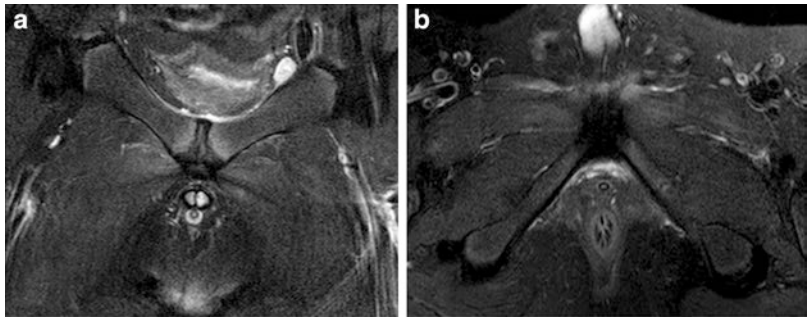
Coronal (a) and axial (b) PD Fat Sat MRI of the pubic symphysis. Rectus abdominis muscle insertion signal change, fiber discontinuity on the left and pubic symphysis osteitis
